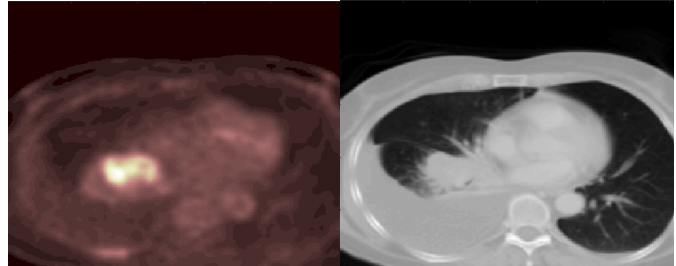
Example of co-registered images from a PET/CT scan of the thorax. Left: PET image, right: CT scan
